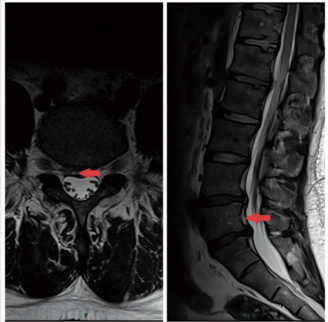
T2-weighted sagittal (left) and axial (right) magnetic resonance images showing the absence of the nucleus pulposus herniation (arrows) 4 months after the initial visit.
